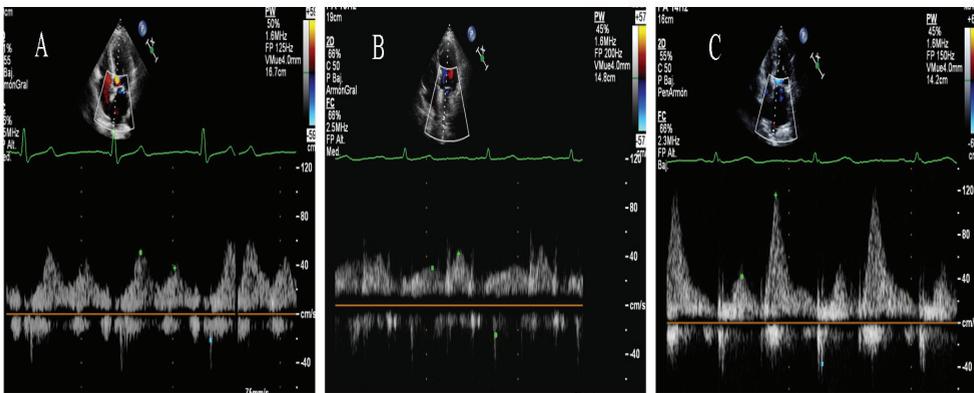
Pulsed Doppler pulmonary blood flow showing: A) Impaired relaxation pattern, B) Pseudonormal pattern C) Restrictive pattern
